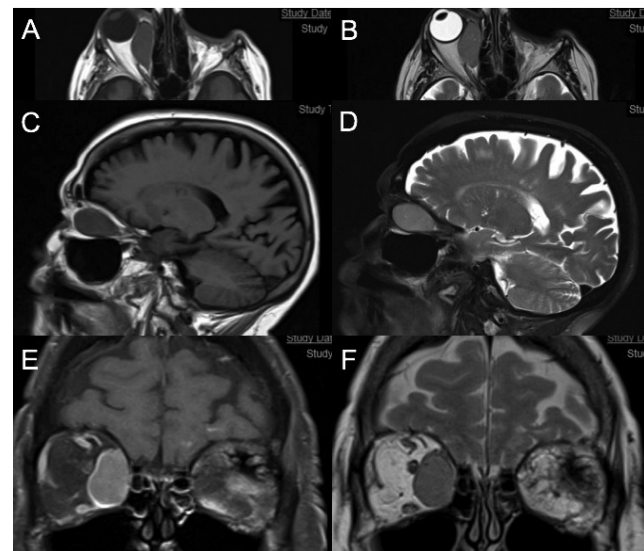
Magnetic resonance imaging of our patient demonstrating a large mass in the right medial rectus: Axial T1 (A) and T2 (B); sagittal T1 (C) and T2 (D); coronal T1, fat suppressed (E), and T2 (F). In general, the mass is hyperintense in T1-weighted images and hypointense in T2-weighted images
